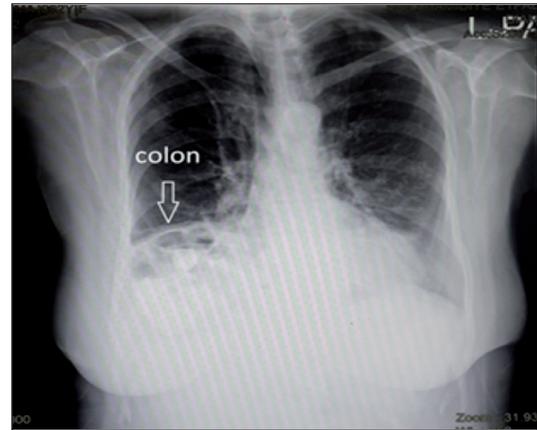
Posteroanterior chest X-ray shows elevated right diaphragm and colonic loops in the right hemithorax.
